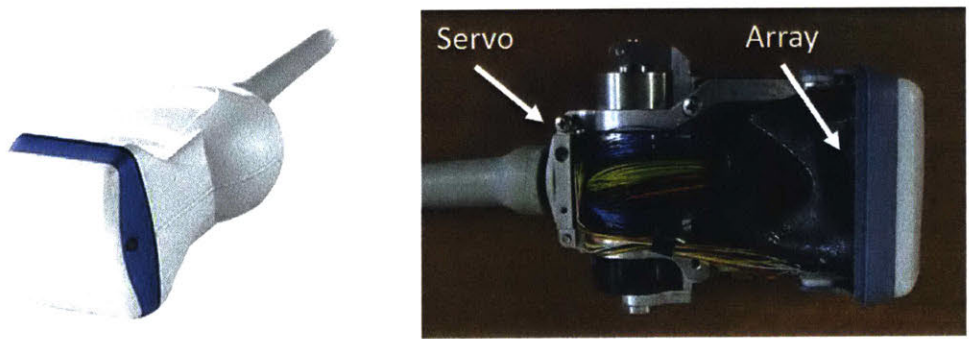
3D ultrasound probe opened to show the mechanical actuation on the array.
